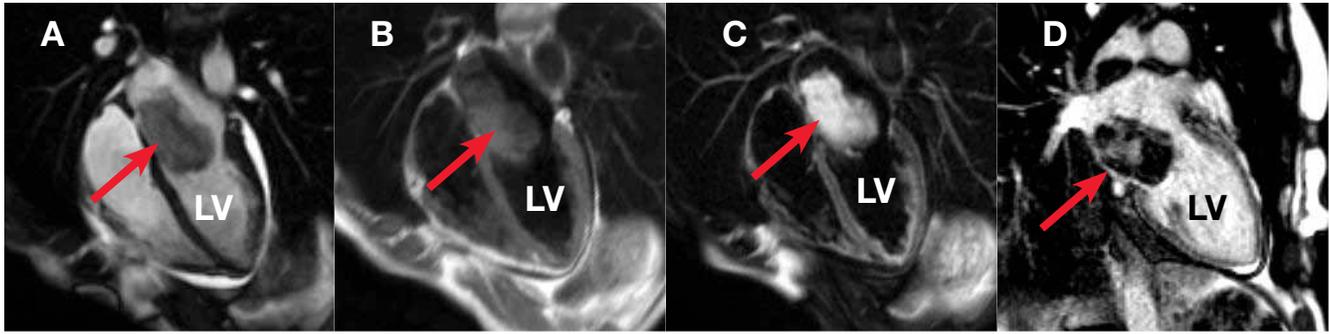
A) Steady state free precession cine sequence demonstrated heterogeneous signal intensity with a sessile attachment to the septal wall. B) The mass was isointense to myocardium on T1-weighted spin-echo imaging and C) was hyperintense to myocardium on T2-weighted spin-echo with fat suppression. D) Areas of delayed hyperenhancement were seen on post-gadolinium contrast imaging. (red arrow: mass; LV: left ventricle).
